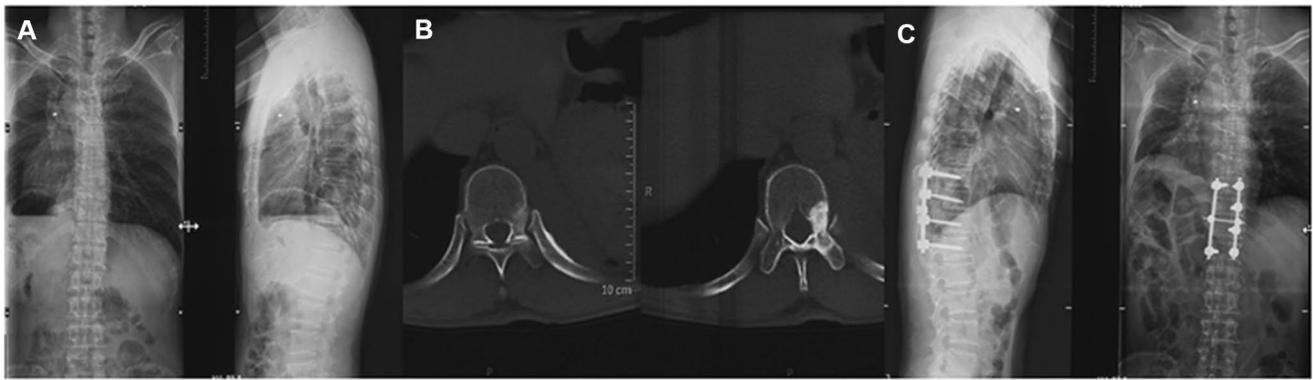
A 59-year-old man (case 1, WHO grade B2) a preoperative X-ray of whole spine; b transverse plane of the T11 level showing the osteoblastic lesion (CT imaging); c postoperative X-ray showing instrumentation
